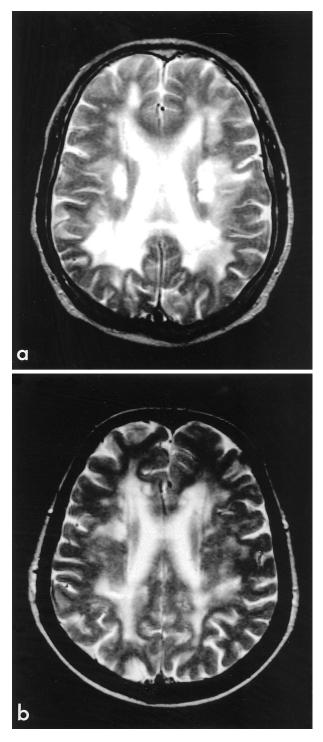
The confluent white matter hyperintensities in the homozygous patient's T2-weighted MRI (a) correspond to the most severe grade D, whereas the changes in the heterozygous reference patient No. 3 (b) of the same age were less severe (moderate=grade C).¹³
